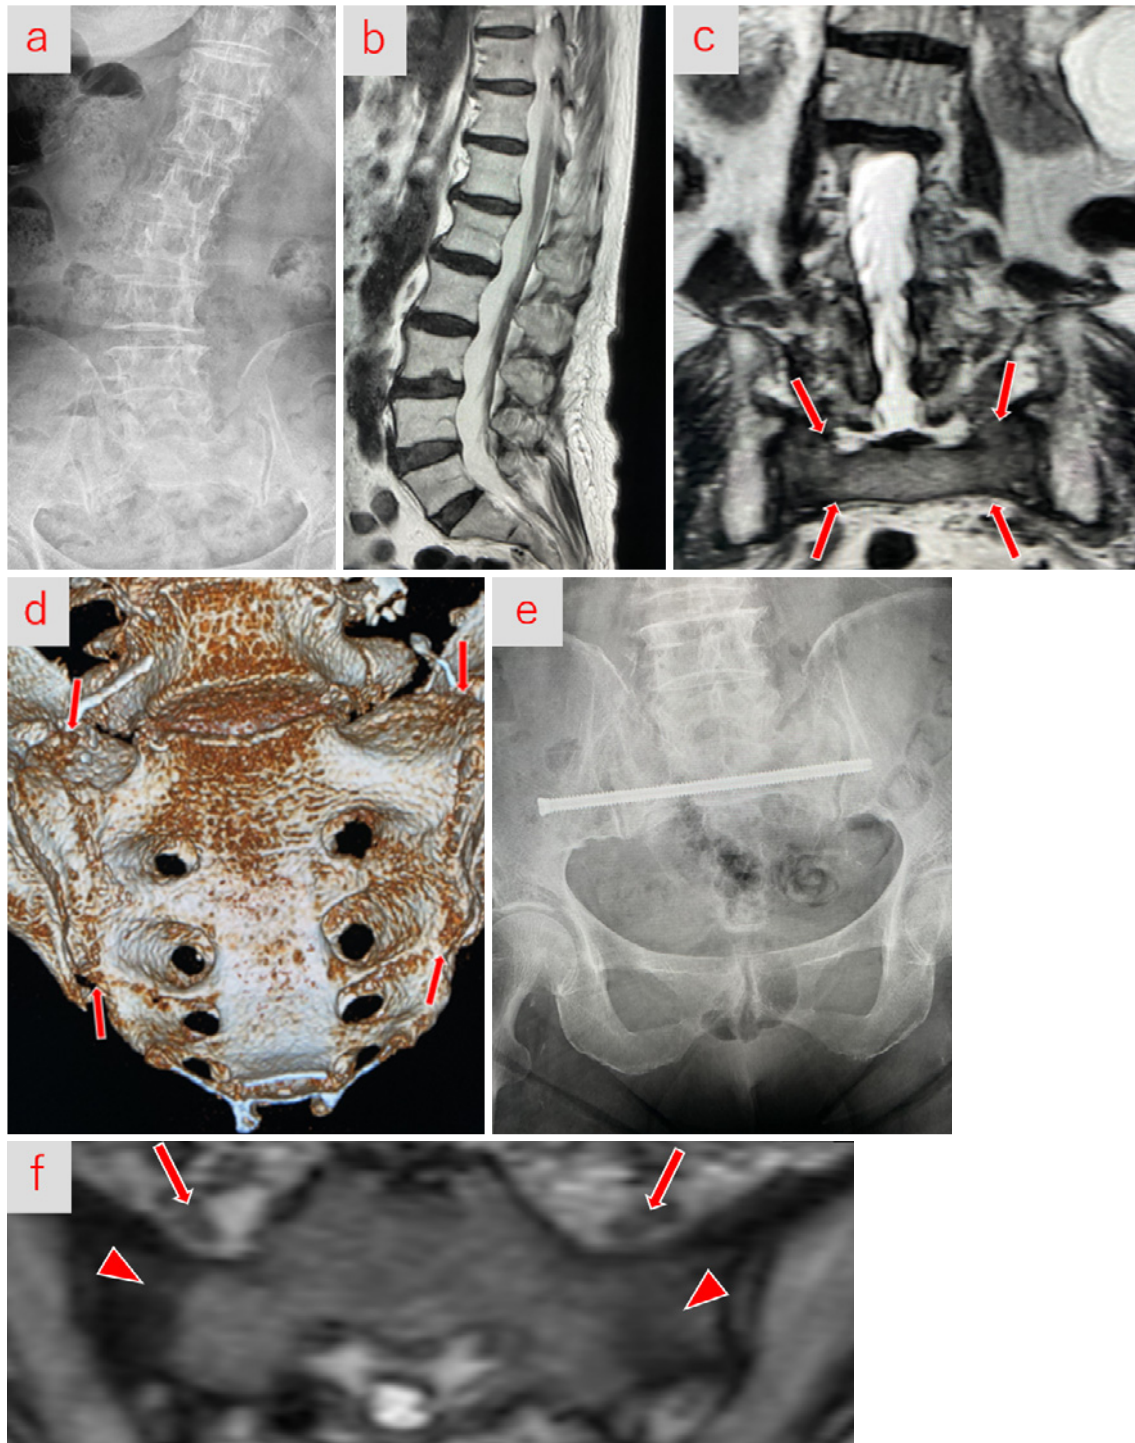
Case 1. a. Preoperative plain radiography showed severe degenerative scoliosis and suspected intervertebral foraminal stenosis. b. The magnetic resonance imaging (MRI) of the lumbar spine did not show evidence of spinal canal stenosis. c. T2-weighted MRI showed a sacral alar insufficiency fracture (arrows). d. Computed tomography (CT) revealed a minimally displaced sacral fracture, Denis classification Zone I, Rommens classification Type IVb, AO classification Type C2 (arrows). e. Postoperative plain radiography after osteosynthesis using transiliac-transsacral screw (TITS). f. T2-weighted MRI showed the L5 nerve roots (arrows) was near the site of the sacral fracture (arrowheads).
